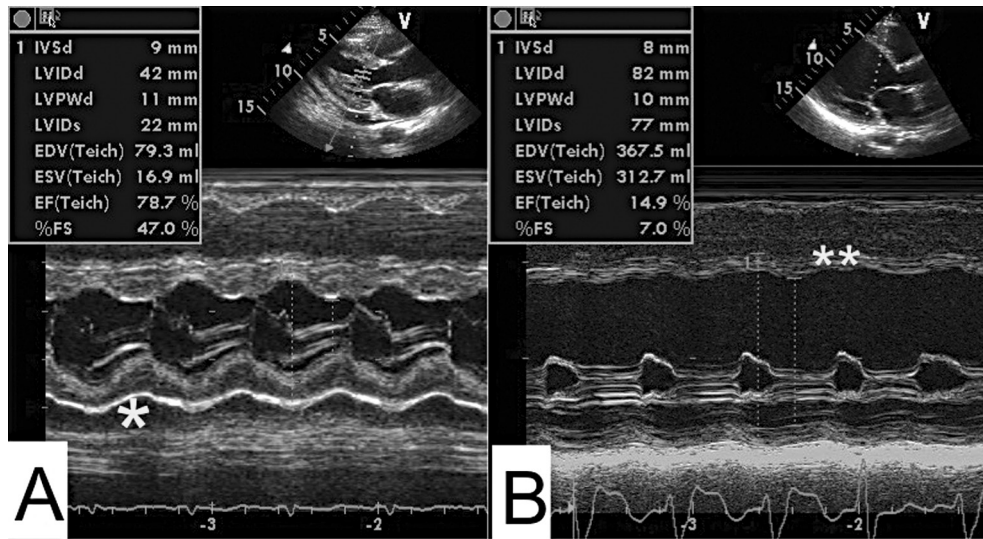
M Mode Left Ventricle and Fractional Shortening. Panel A shows an M Mode obtained from the parasternal long axis of a patient with preserved left ventricular function. This patient suffered from cardiac amyloidosis. Note also the small amount of pericardial fluid indicated by the asterisk (*). Panel B shows a patient with an anteroseptal myocardial infarction with severely diminished LV contractility. The septum is thin scar tissue. Note the absence of systolic thickening of the interventricular septum.
